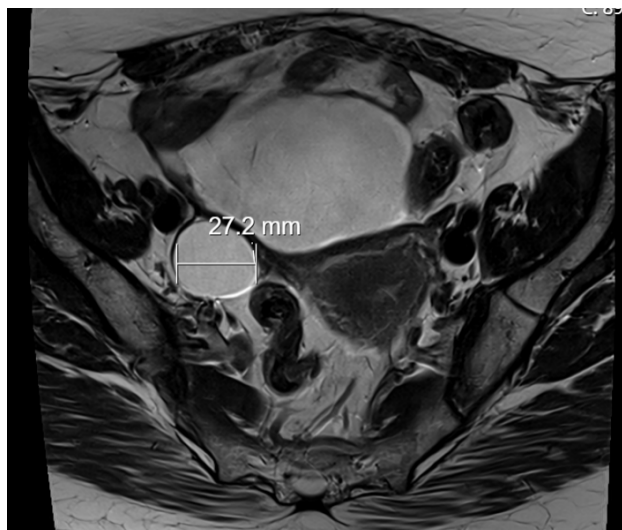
Magnetic resonance imaging (MRI) pelvis. An axial T2-weighted MRI image of the pelvis showing a 27.2 mm diameter (predominantly water signal) right ovarian cyst.
